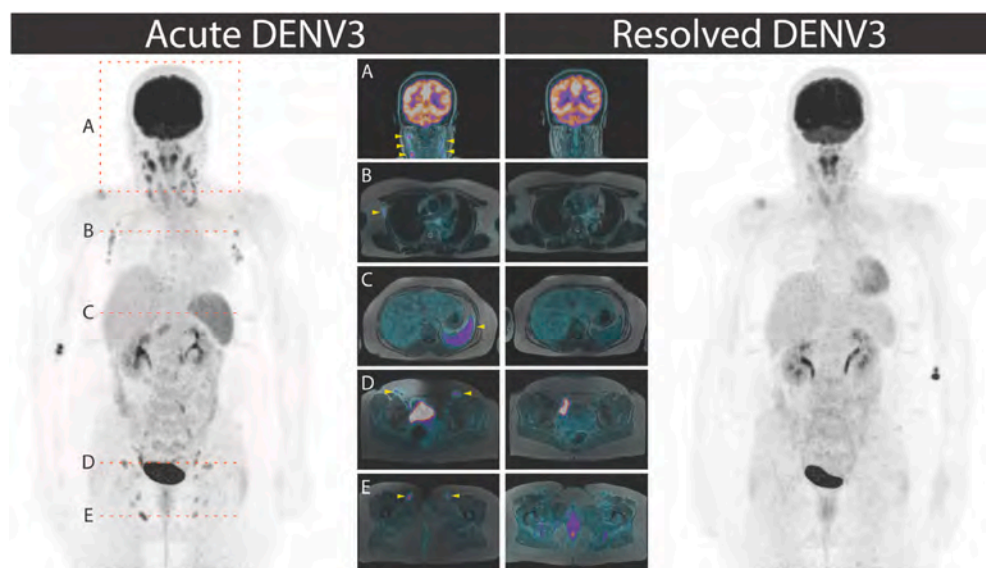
^{18}F -FDG PET/MRI images of Patient A at the time of acute (Day 5 illness) and resolved (convalescent) DENV3 infection. The yellow arrows indicate sites of increased ^{18}F -FDG uptake in the cervical (A; maximum standardized uptake volume of ^{18}F -FDG [SUV_{max}]: 5.4), axillary (B; SUV_{max}: 3.9), external iliac (D; SUV_{max}: 5.9), inguinal and femoral lymph nodes (E; SUV_{max}: 5.4) and spleen (C; SUV_{max}: 4.5) during acute infection. Imaging at convalescence shows metabolic resolution of ^{18}F -FDG uptake at these sites. ^{18}F -FDG uptake seen in the brain, liver and urinary system is physiological and within normal expected limits.
